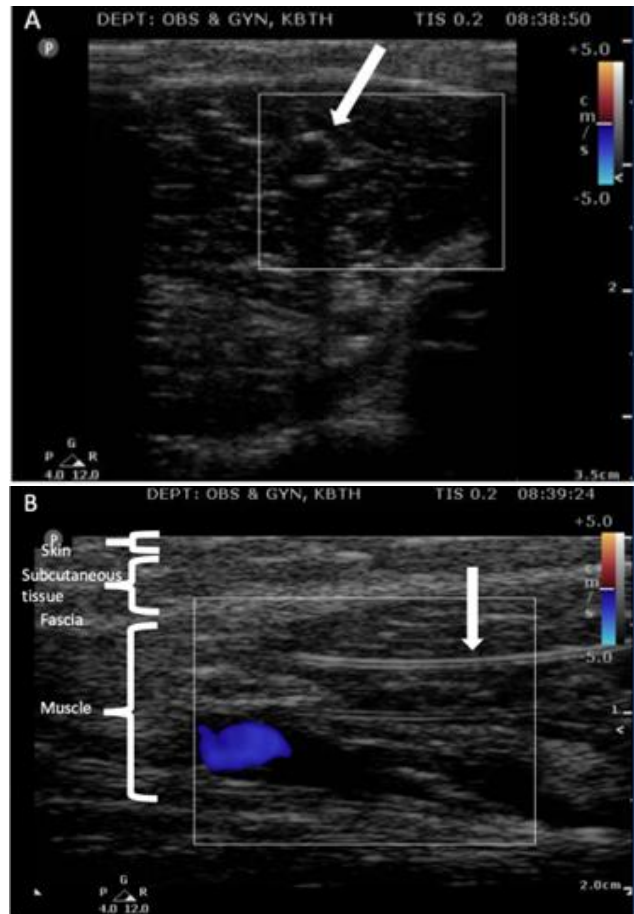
An ultrasound image of contraceptive implant in upper arm
